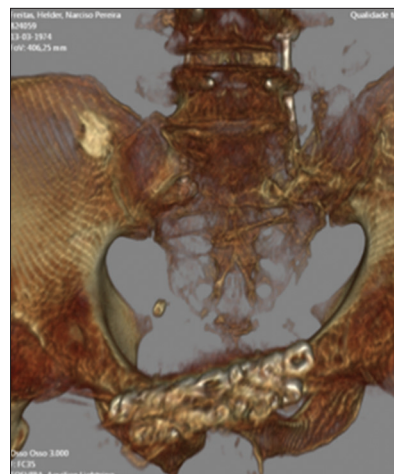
CT 3D reconstruction (1 year follow-up)
